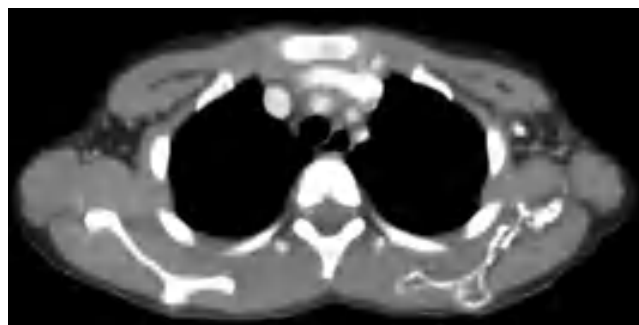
Osteolytic destruction of the left scapula in a patient with Gorham-Stout disease (GSD). Axial CT image of the left scapula demonstrates intramedullary lucent lesions with cortical thinning.
